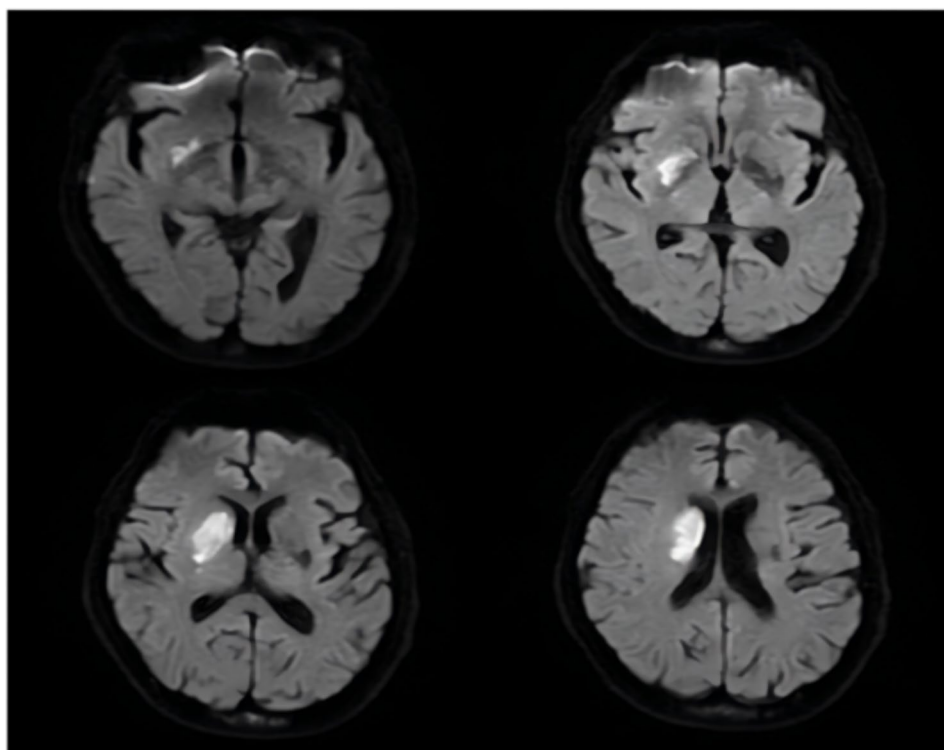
Diffusion-weighted magnetic resonance imaging shows hyperintensity over the right basal ganglia and beside the lateral ventricle, while hypointensity is observed over the left basal ganglia and beside the lateral ventricle (Residual lesions of previous cerebral infarction)
